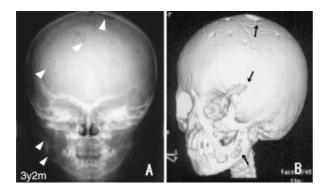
Cephalometric radiograph (A) and helical computed tomography (B) showing the multiple well-defined osteolytic lesions in the skull and mandible (arrowhead and arrow).
